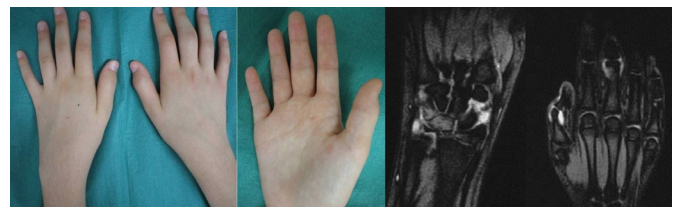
A 12-year-old girl presented with a six-month history of swelling and restricted movement of the right middle finger and one month of similar symptoms in the left wrist. She was afebrile, and laboratory results were normal except for a positive antinuclear antibody titer of 1:80. MRI showed inflammatory joint fluid in the left wrist, metacarpophalangeal joint of the thumb, right proximal interphalangeal joint of the middle finger, and the interphalangeal joint of the thumb.
